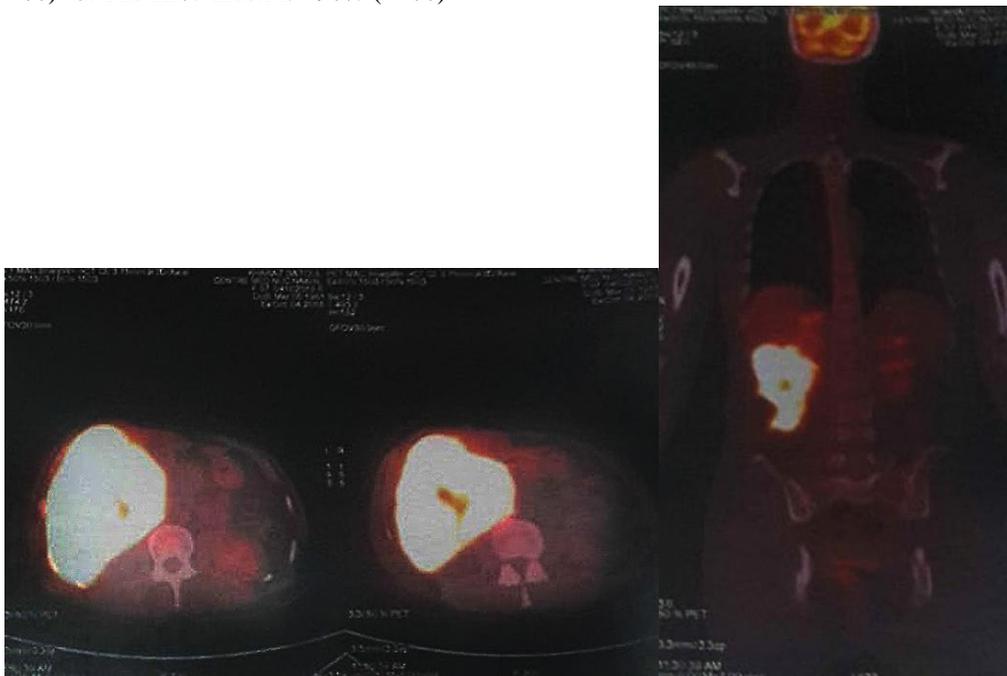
B: large hypermetabolic tumor of the liver (SUVmax = 18.6) occupying almost the entire right liver measuring 109x153x150 mm with hypermetabolic hepatic hilar lymph nodes (SUVmax = 13.8)
